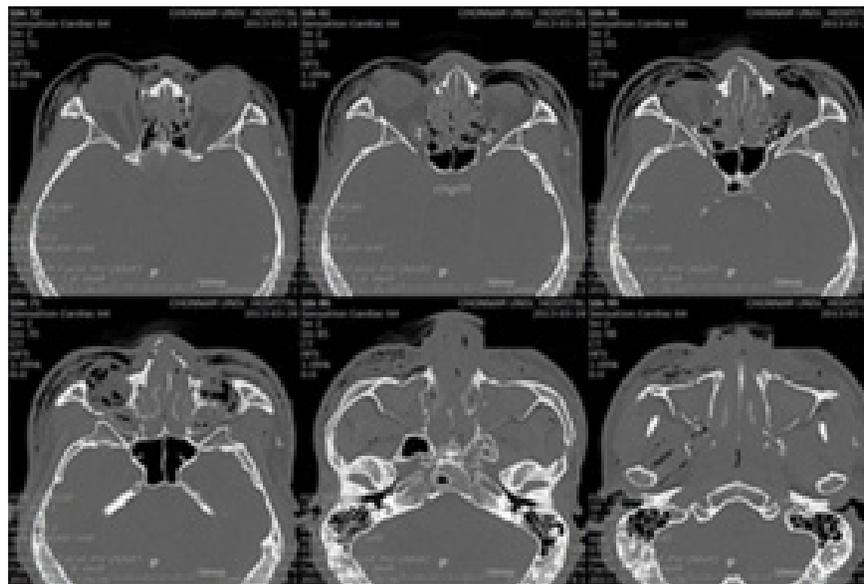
CT examination showed Le Fort I, II and III fracture.
